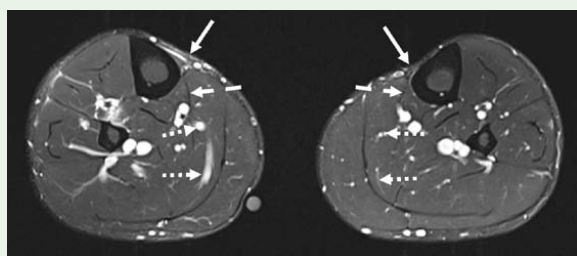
27-year-old elite national Australian Rules Football (ARF) player with right calf tightness post-game. Bilateral axial T2-FS calf MRI with oil bead indicating the region of clinical interest. No acute right calf tear has been demonstrated. However, there is evidence of low-grade right calf injury, with loss of soft tissue concavity at the posterior border of the tibia (arrow), indicating mild generalized calf swelling, and dilatation of the soleal veins, when compared to the left (dotted arrow). The right medial intra-muscular aponeurosis is subtly thickened when compared with the left (dashed arrow), indicating possible micro-tearing.
